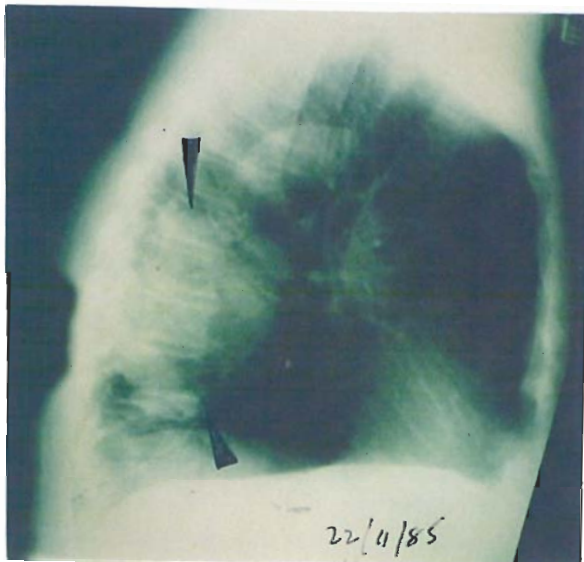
A lateral x-ray taken on 22 November 1985. Treated January 1986. A large mass is seen attached to the posterior wall of the chest (arrowed).
